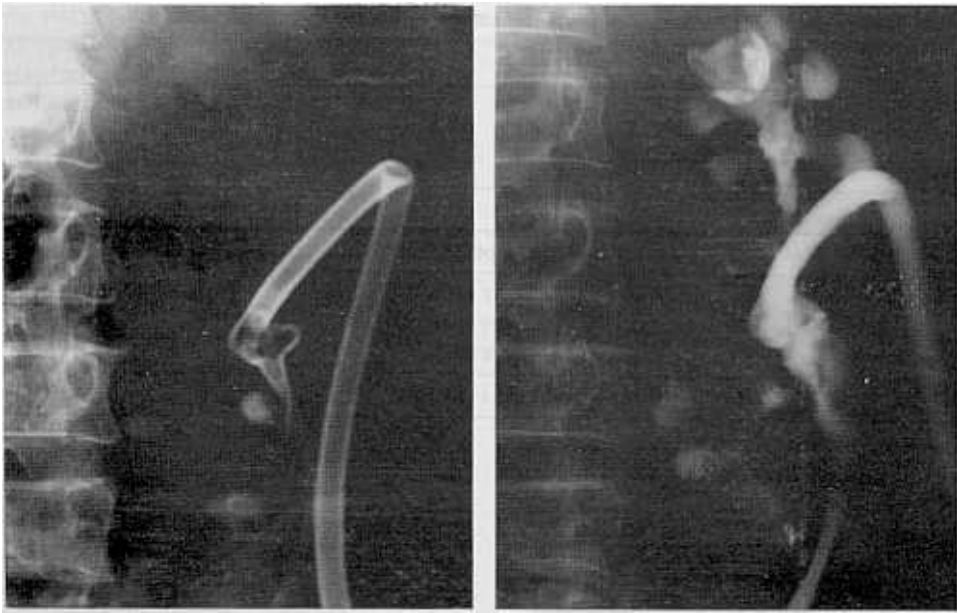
Plain abdominal radiograph following first session percutaneous ultrasonic lithotripsy shows three residual fragments. A reentry nephrostomy catheter (24-F shaft) is in place. Nephrostogram shows patency of the renal collecting system. Stone fragments are in the minor calices.
